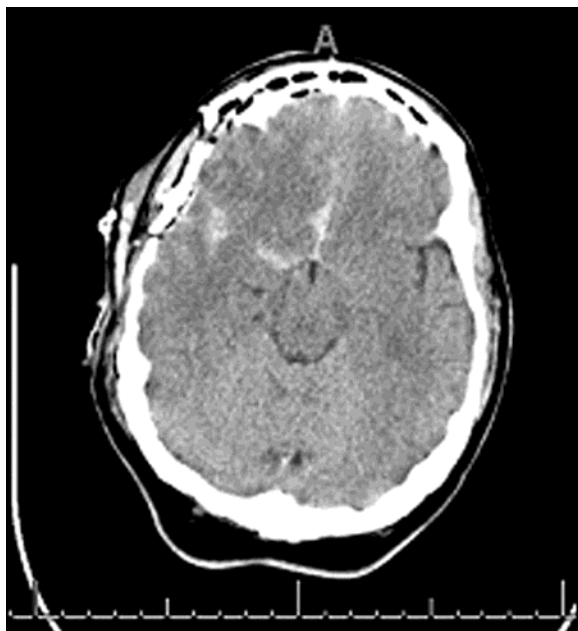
Postoperative axial computed tomography scan showing subarachnoid blood in the basal cisterns and particularly in the right sylvian fissure.
